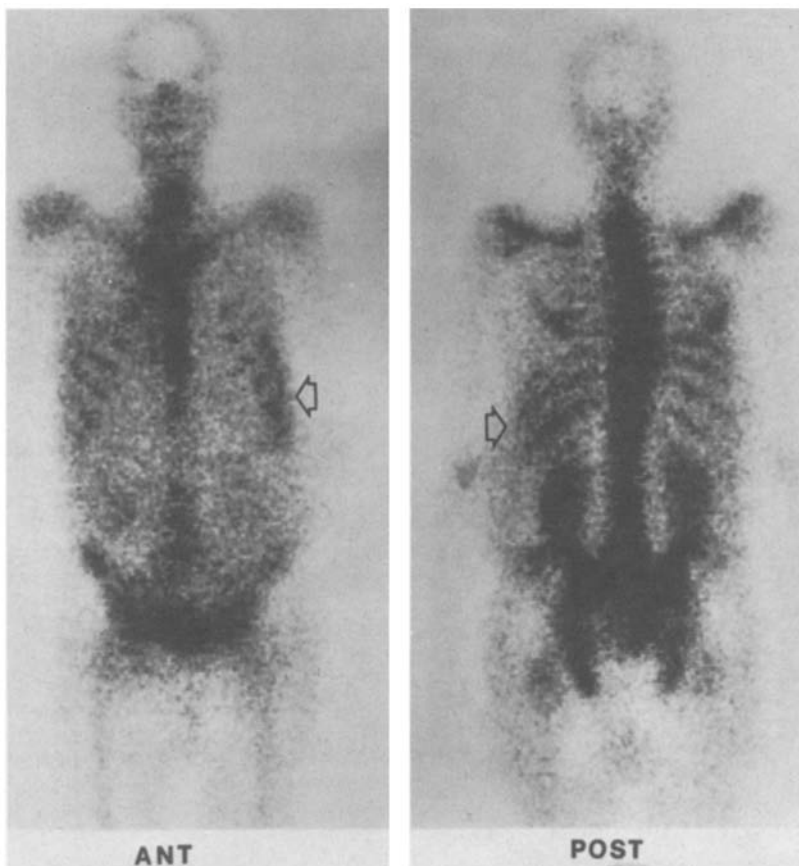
Technetium-99m SC scintigrams.
